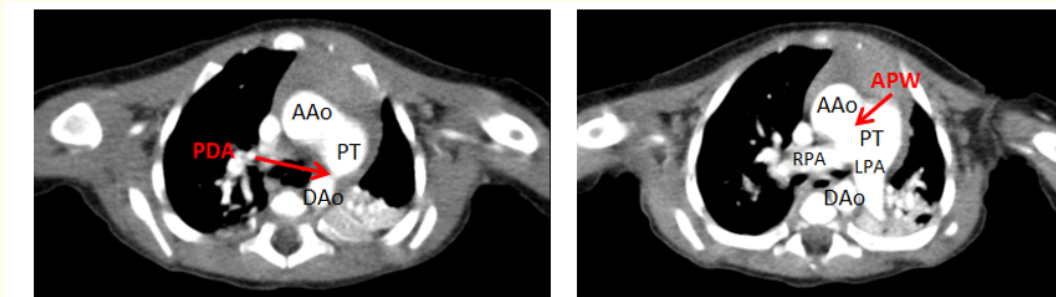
Axial contrast enhanced CT demonstrating the associative anomalies in 2D: APW, PDA in addition to IIA diagnosed by the following of the aortic tract on the console.
